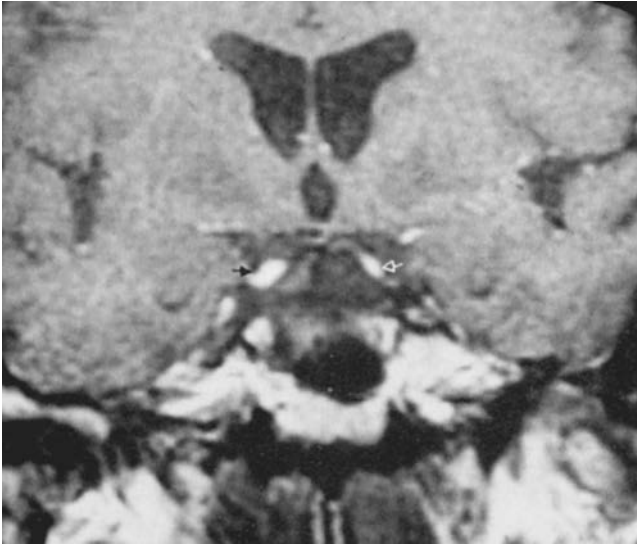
Primary large-cell lymphoma of the optic chiasm. The patient was a 58-year-old woman with progressive loss of vision. *A*, Axial computed tomographic scan after intravenous injection of iodinated contrast material shows an enhancing mass in the suprasellar region (*open arrows*). Right middle cerebral artery (*short arrow*) and left anterior cerebral artery (*long arrow*) are also seen. *B*, T1-weighted coronal magnetic resonance image shows marked enlargement of the optic chiasm (*black arrows*). The infundibulum (*thin white arrow*), pituitary gland (*open arrow*), and intracavernous carotid arteries (*thick white arrows*) appear normal. A biopsy of the lesion established the diagnosis. (From Gray RS, Abrahams JJ, Hufnagel TJ, et al. Ghost-cell tumor of the optic chiasm: Primary CNS lymphoma. *J Clin Neuroophthalmol* 1989;9:98–104.)
